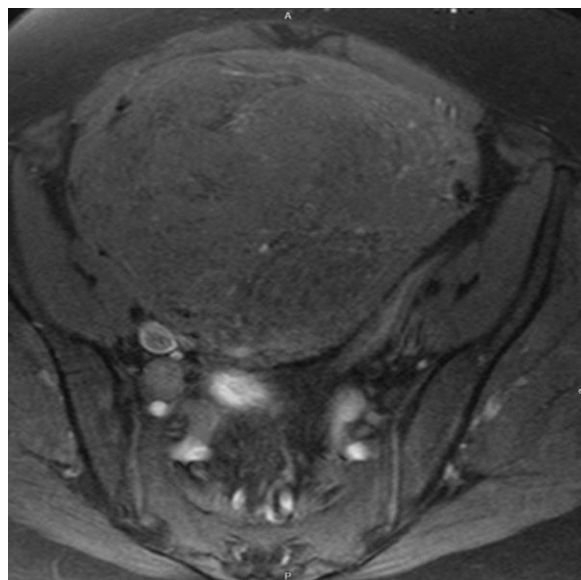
MRI Pelvis- showing uterine mass
